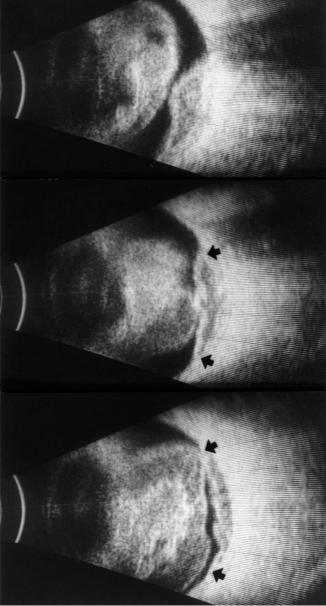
Ultrasound photographs, from three angles, of a massive subretinal hemorrhage with a vitreous hemorrhage in a patient with age-related macular degeneration
